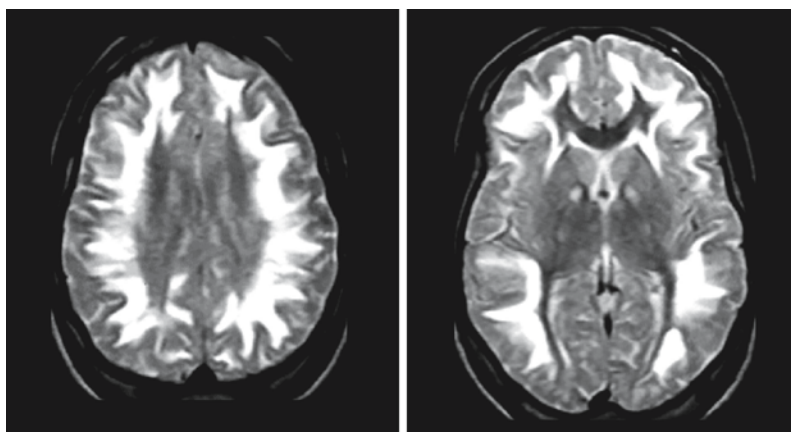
In mitochondrial encephalopathy with lactic acidosis and stroke-like episodes (MELAS) the lesions have an infarct-like appearance on MR images, as shown on these transverse FLAIR images in a 9-year-old girl, but do not, as a rule, respect vascular territories. (Courtesy of Dr. M. Heitbrink and Dr. B. Wiarda, Department of Radiology, Medical Center Alkmaar, The Netherlands)
